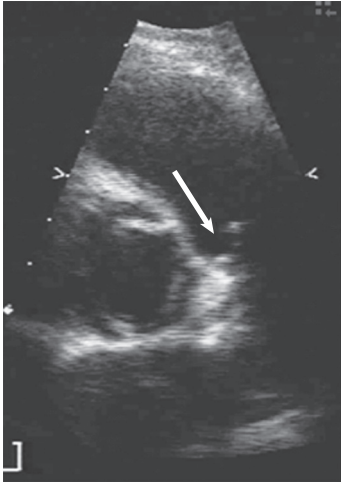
Systolic parasternal short-axis view demonstrating systolic doming of this congenitally stenotic pulmonic valve (*arrow*). In real time the valve has a jump rope appearance.
